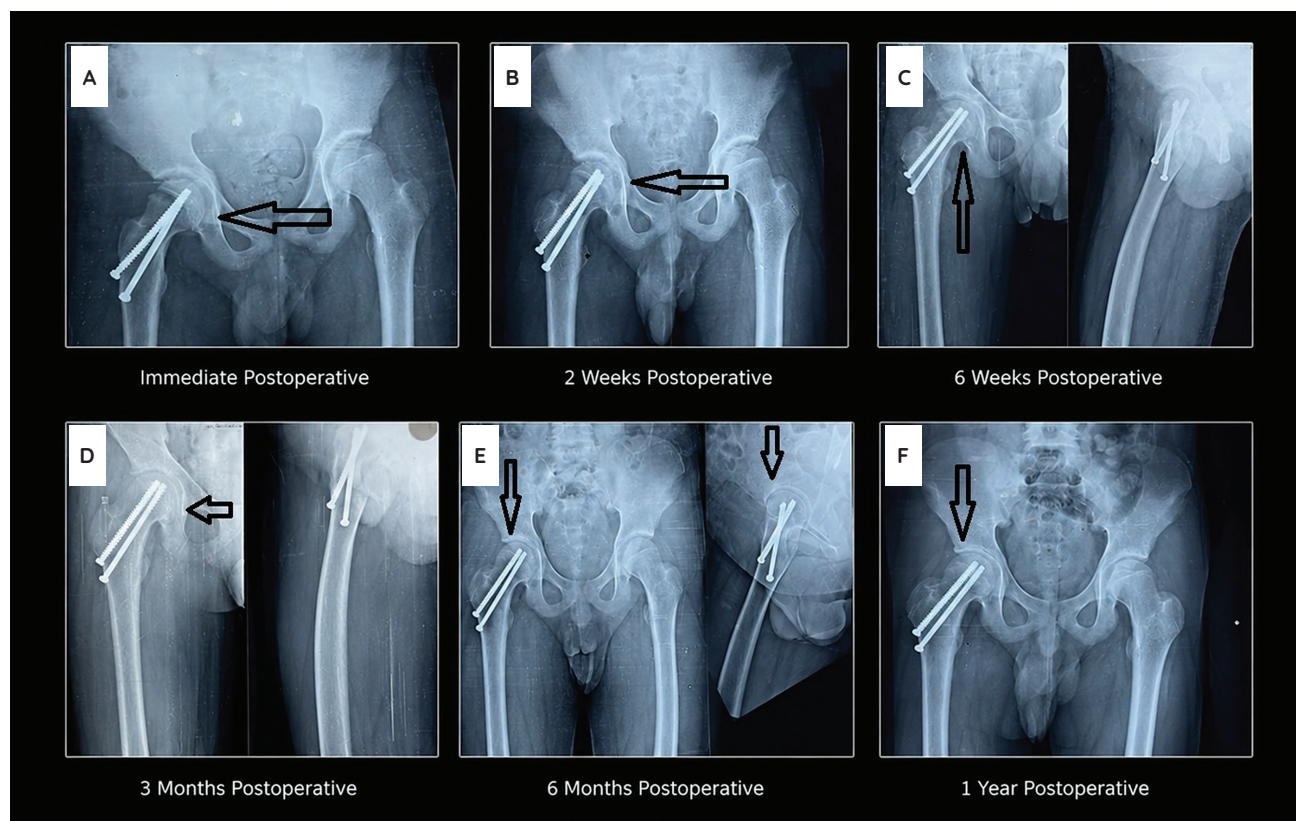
Serial radiographic evaluation of a 15-year-old male with acute traumatic slipped capital femoral epiphysis managed with dual 4.0 mm screw fixation. Immediate postoperative radiographs showing satisfactory closed reduction and placement of dual cannulated screws within the femoral epiphysis without joint penetration (A). Two-week follow-up demonstrating maintained reduction and stable implant position (B). Six-week follow-up showing progressive healing without loss of fixation (C). Three-month follow-up with continued stability and early signs of physeal closure (D). Six-month follow-up radiographs demonstrating maintained alignment and absence of femoral head collapse (E). One-year follow-up showing complete physeal fusion with no radiographic evidence of avascular necrosis or joint space compromise (F).
